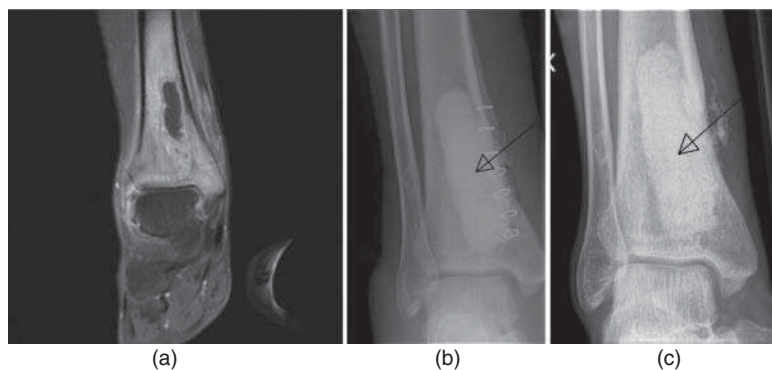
Treatment of osteomyelitis caused by *Staphylococcus aureus* in the distal tibia: (a) preoperative magnetic resonance images showing osteomyelitis, (b) postoperative X-ray showing S53P4 in the treated cavity (arrow), and (c) X-ray at five months showing the treated region (arrow). Source: Lindfors et al. [46]/with permission from Elsevier.
